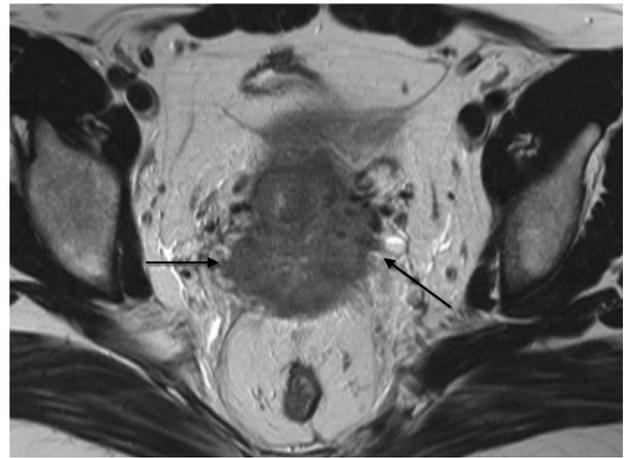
A key determination is the presence or absence of parametrial invasion. Abnormal signal intensity disrupting the cervical stroma is a reliable indicator of parametrial invasion. Axial T2-weighted MRI reveals a large cervical tumor with parametrial extension, Stage IIB (arrows).
